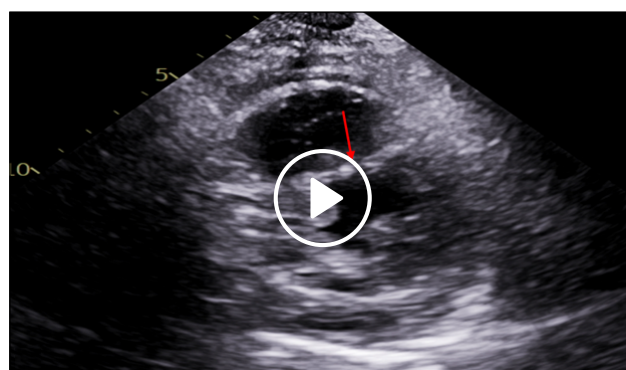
Persistent constrictive physiology following pericardial drainage. Cardiac magnetic resonance (CMR) imaging and transthoracic echocardiography obtained after therapeutic pericardiocentesis (600 mL drained) demonstrate persistent features of constrictive physiology. Panel A shows a CMR image with respirophasic interventricular septal shift (arrow; corresponding motion shown in [Video 3](#)). Panel B demonstrates residual pericardial effusion with persistent interventricular septal flattening on post-drainage echocardiography (arrow; corresponding motion shown in [Video 4](#)). Panels C and D show tissue Doppler imaging of the mitral annulus, with accentuated medial e' velocity exceeding the lateral e' velocity, consistent with persistent annulus reversus after relief of tamponade.
